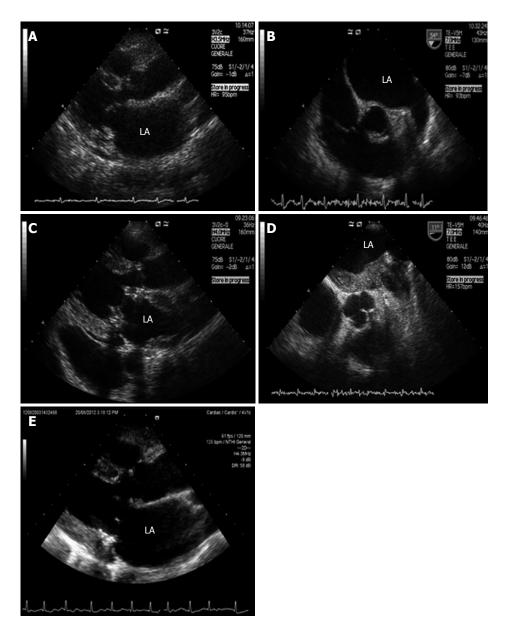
Echocardiographic image. A: Left parasternal long axis transthoracic echocardiography; B: Upper transesophageal views of the aortic valve in short axis; C: Left parasternal long axis transthoracic echocardiography; D: Upper transesophageal views of the aortic valve in short axis; E: Left parasternal long axis transthoracic echocardiography. LA: left atrium.
